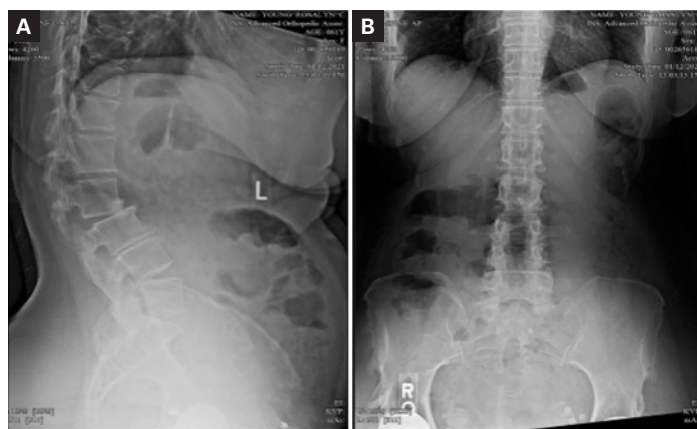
Pre-operative imaging. (A, B) AP and lateral X-rays, respectively, demonstrating 30 degrees segmental kyphosis and progressive instability at L2-L3. Pelvic incidence, 35 degrees. Lumbar lordosis, 8 degrees.
